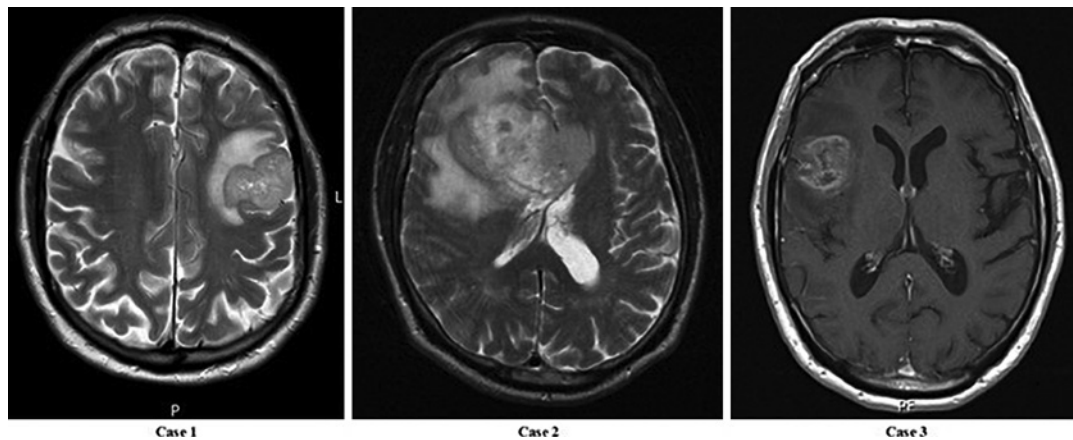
Axial MRI scans demonstrating lesions suggestive of malignant tumour with surrounding vasogenic oedema (T2 weighted images – Cases 1 and 2; gadolinium-enhanced T1-weighted image – Case 3).
